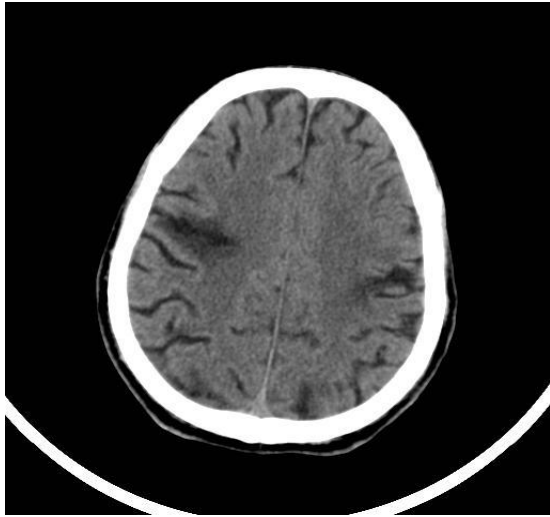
CT scan of Male patient with Parkinson's disease. Total brain atrophy.
